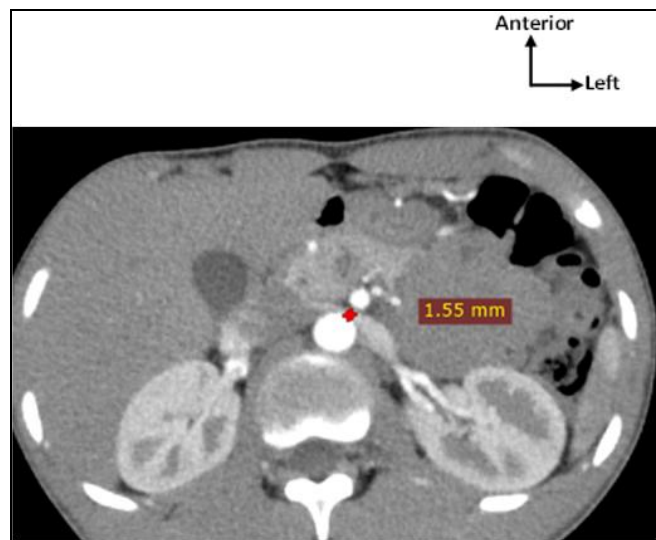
Abdominal CT scan in axial section at arterial phase showing compression of the left renal vein measuring 1.5 mm in the aorto-mesenteric clamp
